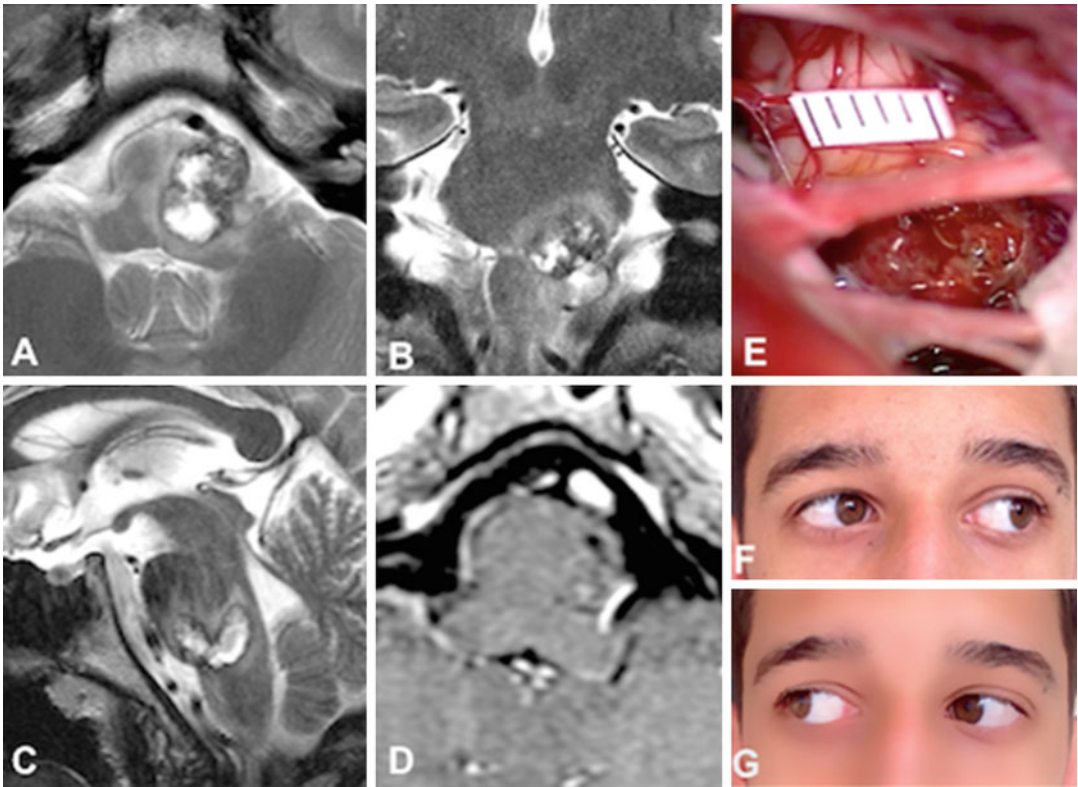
Preoperative axial T1w (a) and coronal (b) and sagittal T2w MRI (c) of a 3-year-old girl showing a large residual and rebleeding CM of the anterolateral aspect of the pons (the child was operated on elsewhere when she was 2 years old after a first hemorrhage causing left hemiparesis, right facial nerve palsy, and walking
